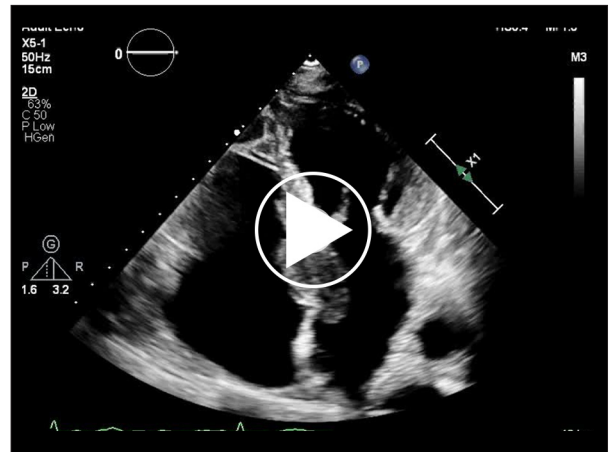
Large interatrial septal mass on the initial echocardiogram. Apical 4-chamber view by transthoracic echocardiogram obtained on presentation showed a large cardiac mass (3.6×3.7 cm) in the interatrial septum.
